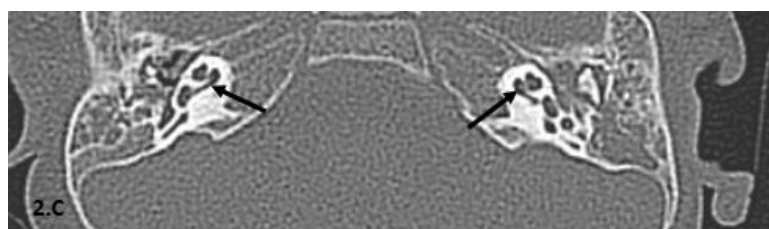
C: Axial CT, bone window view revealed bilateral average cochlear morphology with normal cochlear turns.
